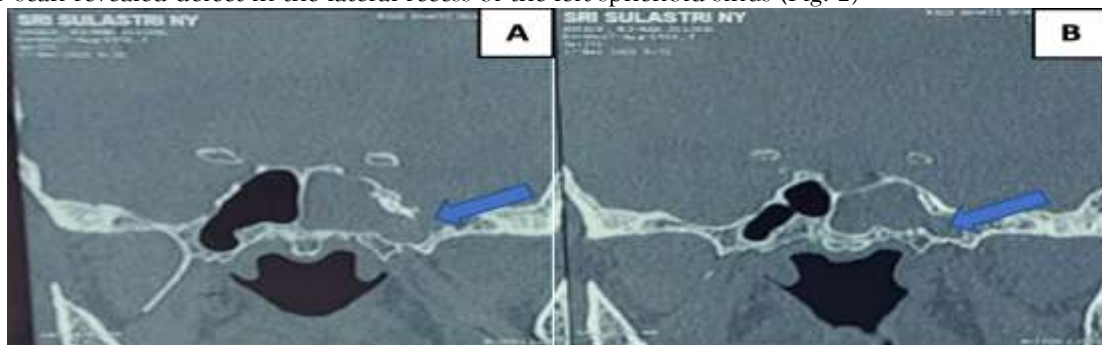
Paranasal sinus CT scan. (A) Defect in the lateral recess of the left sphenoid sinus (blue arrow). (B) Hyperdense fluid appearance consistent with meningocele (blue arrow).
